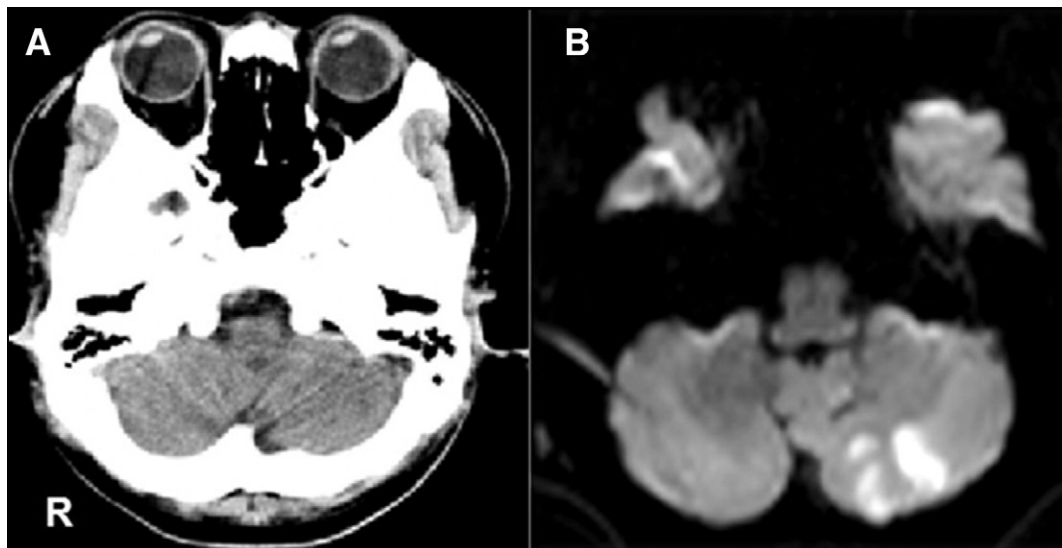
A 37-year-old male complaining of vertigo without neurological deficit. Head CT on admission revealed conjugate eye deviation to the right (A) and diffusion-weighted imaging revealed acute cerebellar lesion in the territory of the left posterior inferior cerebellar artery (B).
